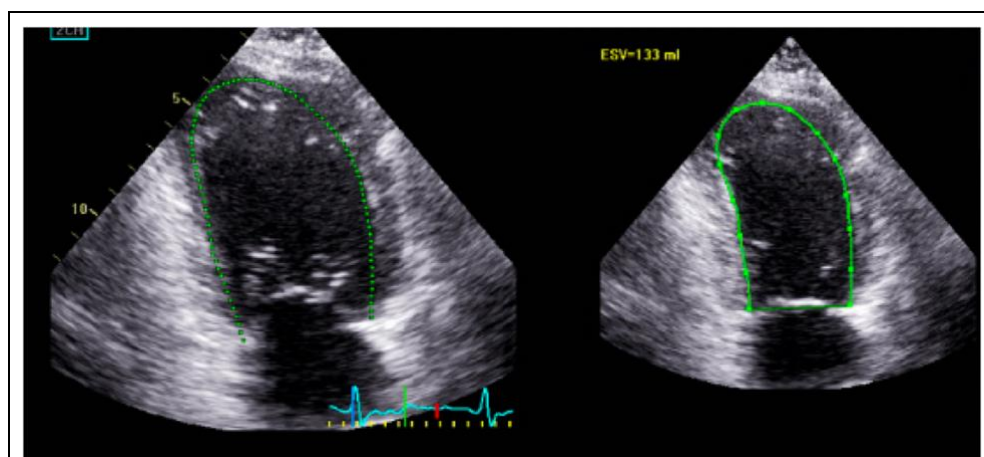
Echocardiographic evidence of reduced ventricular systolic function prior to CABG.
